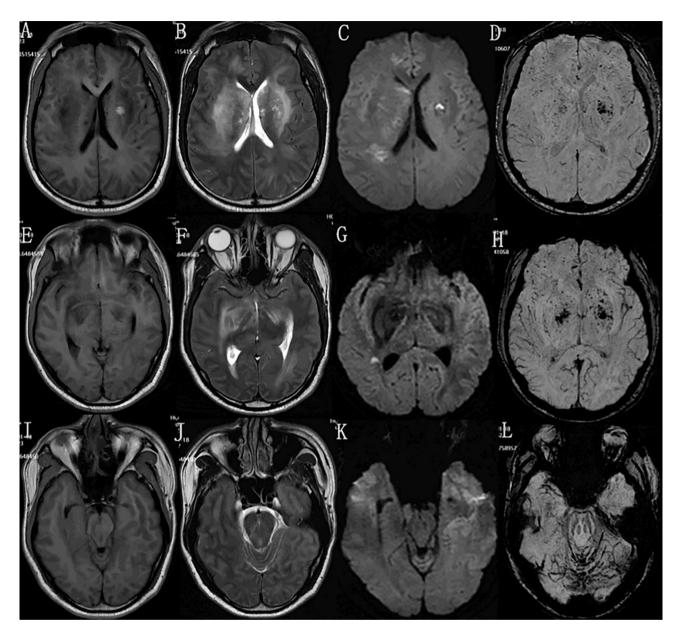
Patient 3 Encephalitis in a 35-year-old male presenting with fever, seizure and coma. Axial T1-weighted (A, E, I) and T2-weighted (B, F, J) images show abnormal signals in the basal ganglia region, corona radiata, bilateral frontal and temporal regions and pons. Axial diffusion-weighted image (C, G, K) reveals decreased diffusion (high signal intensity) in the same regions. SWI (D, H, L) images reveal dispersed microhaemorrhages in the above lesions that are predominantly located in the basal ganglia and bilateral cerebellar hemispheres
